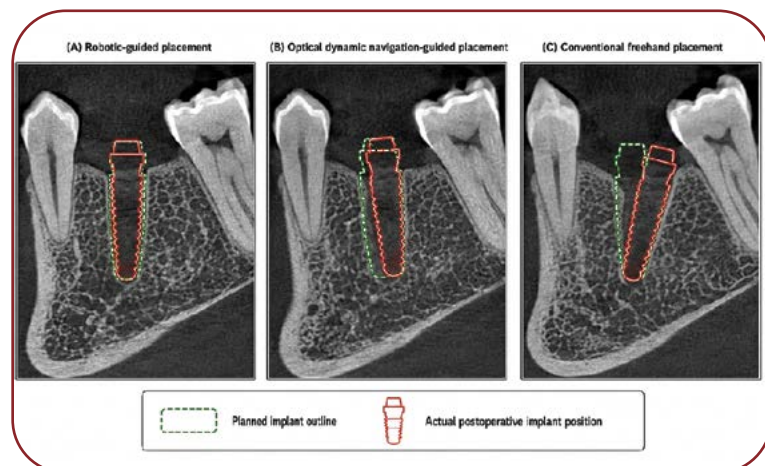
Representative CBCT-based superimposition of planned and postoperative implant positions should be inserted here as three matched panels: (A) robotic-guided placement; (B) optical dynamic navigation-guided placement; and (C) conventional freehand placement
